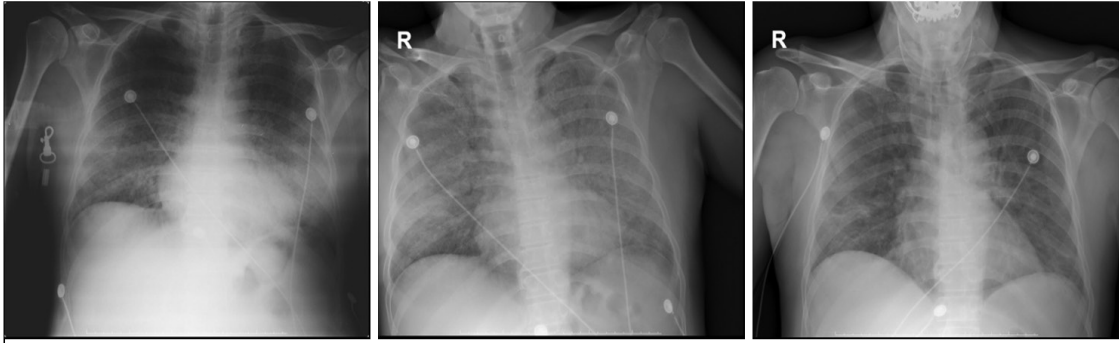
Chest radiographs of the patient from left to right; on admission, three days after admission, six days after admission.
